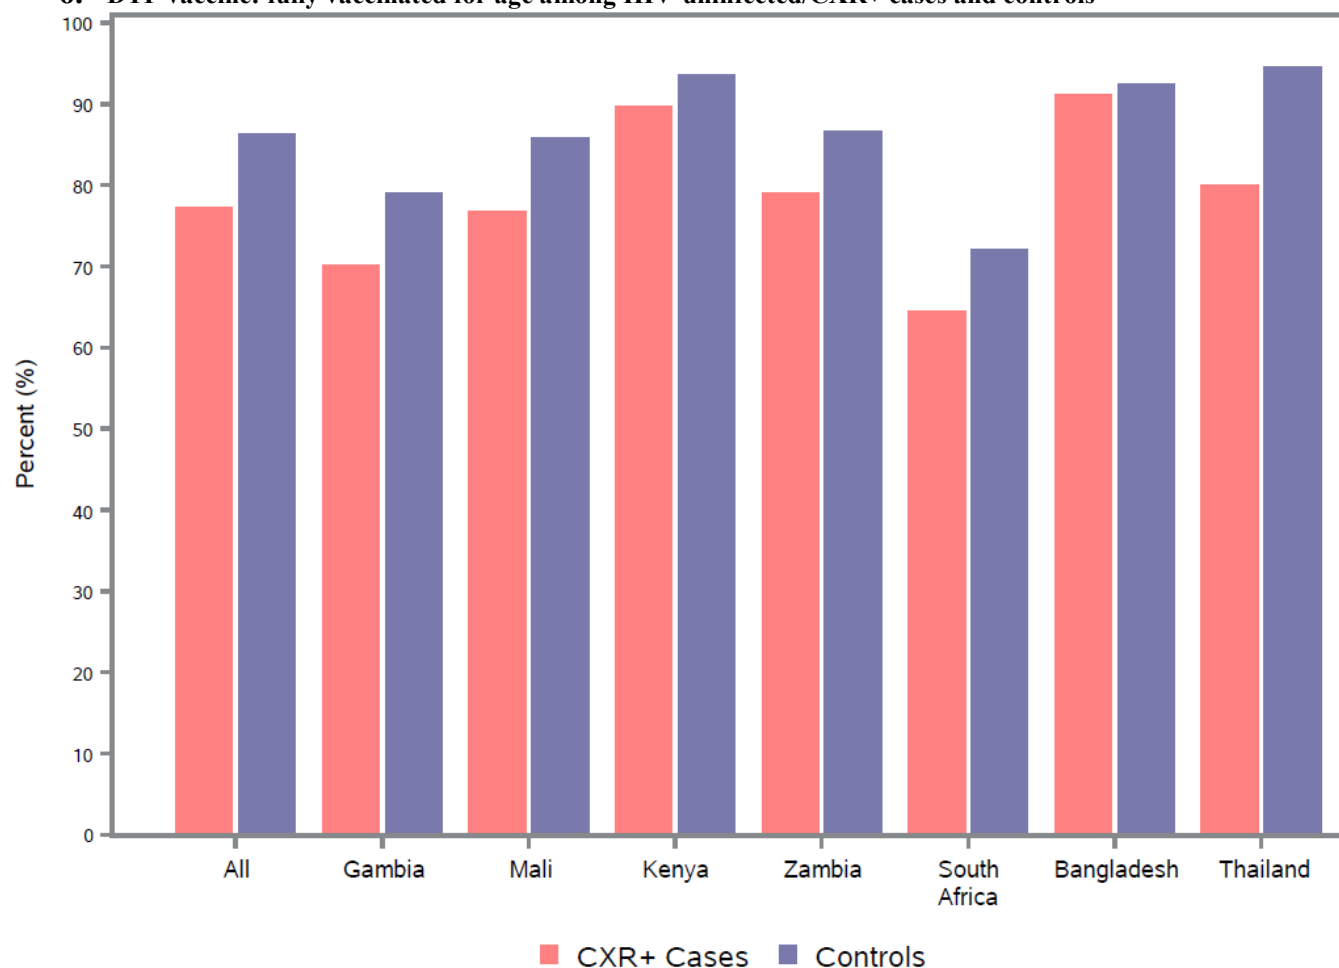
Abbreviations: CXR+, abnormal chest radiograph.
